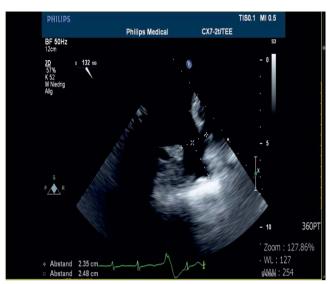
Respectively on an echocardiographic view angle of 132°.
